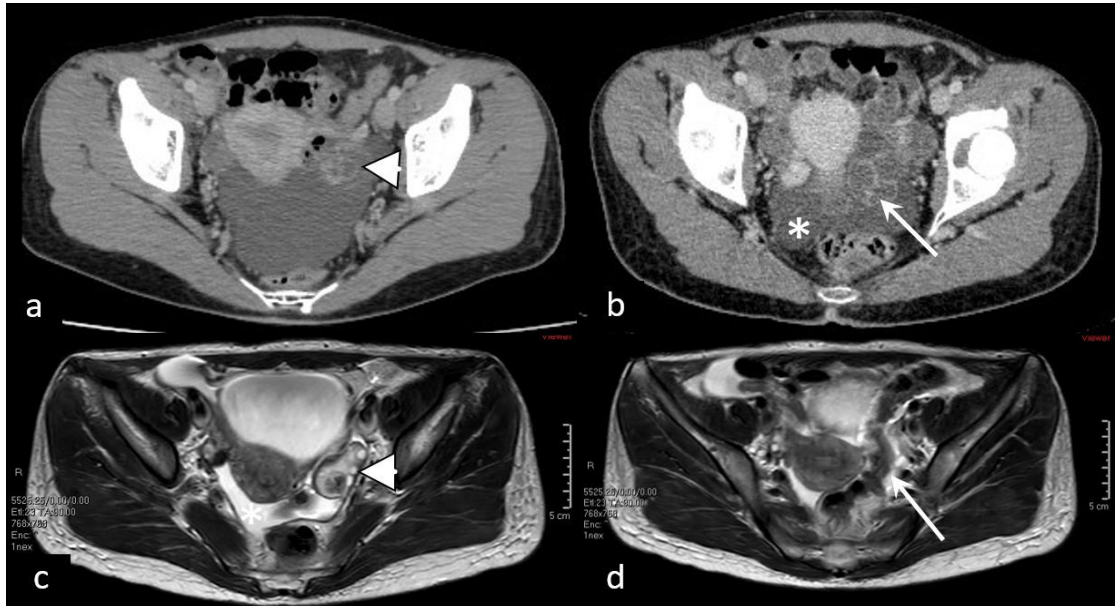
Contrast-enhanced CT (a, b) shows slightly enlarged, in homogenous left ovary - Jean-Luc Brun et al. (2020)
